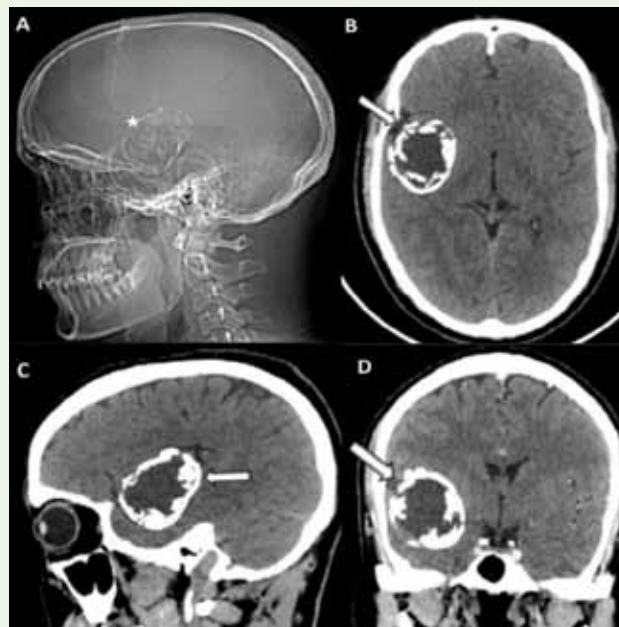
Case of a 36-year-old male with weakness on the left side of the body. Image A is a lateral skull radiograph showing a well-defined radio-opaque (calcified) intracranial lesion (marked by a white star). Computed tomography axial section (Image B) with sagittal (Image C) and coronal (Image D) MPR reconstruction of the brain in soft tissue window reveals a well-circumscribed calcified mass in the anterior temporal region with peripheral arch-like calcification (marked by white arrow).
